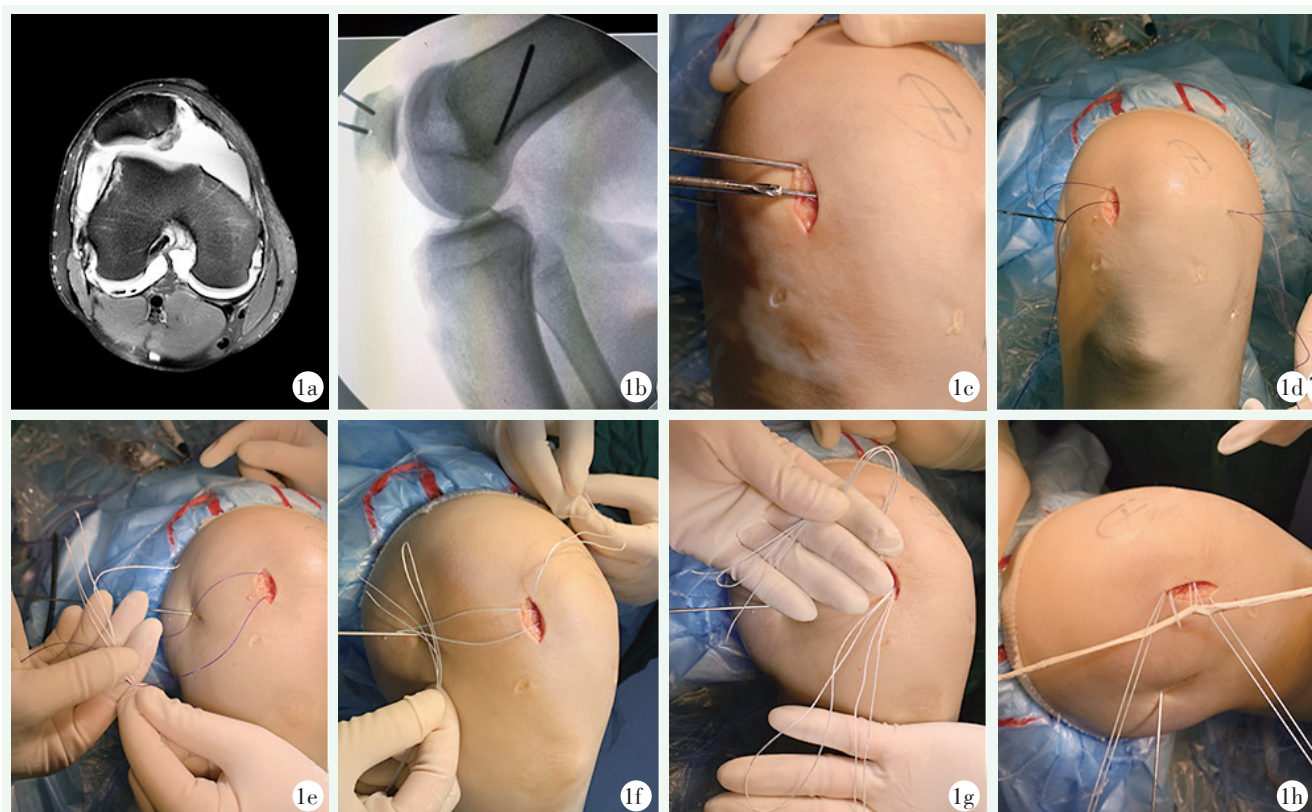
患者男性, 18 岁。1a: 术前右膝 MRI 示右膝髌骨向外侧半脱位; 1b: 透视定位重建内侧髌股韧带髌骨侧及股骨位隧道口; 1c: 髌骨内侧钻入 2 枚带尾孔导针, 4.5 mm 空心钻进行扩隧道, 以制作 5 mm 浅隧道; 1d: 利用导针各引入 1 根 PDS 线环; 1e: 将 PDS 线在髌骨外侧面使用血管钳皮下分离, 经小切口引出, 剪断 PDS 线, 分别与另一骨道的 PDS 线打结, 还纳入至髌骨外缘; 1f: 2 条 PDS 的一端线分别与 1 个缝线束环打结, 牵拉 PDS 线, 将缝线环自一个骨道内侧口, 从另一个骨道内侧口引出; 1g: 每一骨道内侧口分别形成一个缝线环和另一骨道缝线环及线尾; 1h: 肌腱移植套入双线环中, 同时收紧两个线尾, 使肌腱与隧道紧密贴合, 收紧线环, 打结固定移植腱的髌骨侧。
